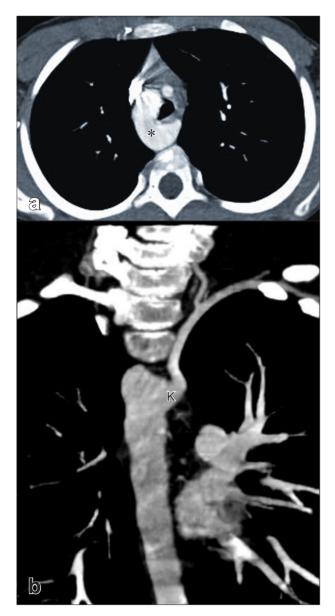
a) Axial CT image shows right aortic arch (asterisk). b) Coronal MIP image shows ALSA arising from a diverticulum of Kommerell (K).
